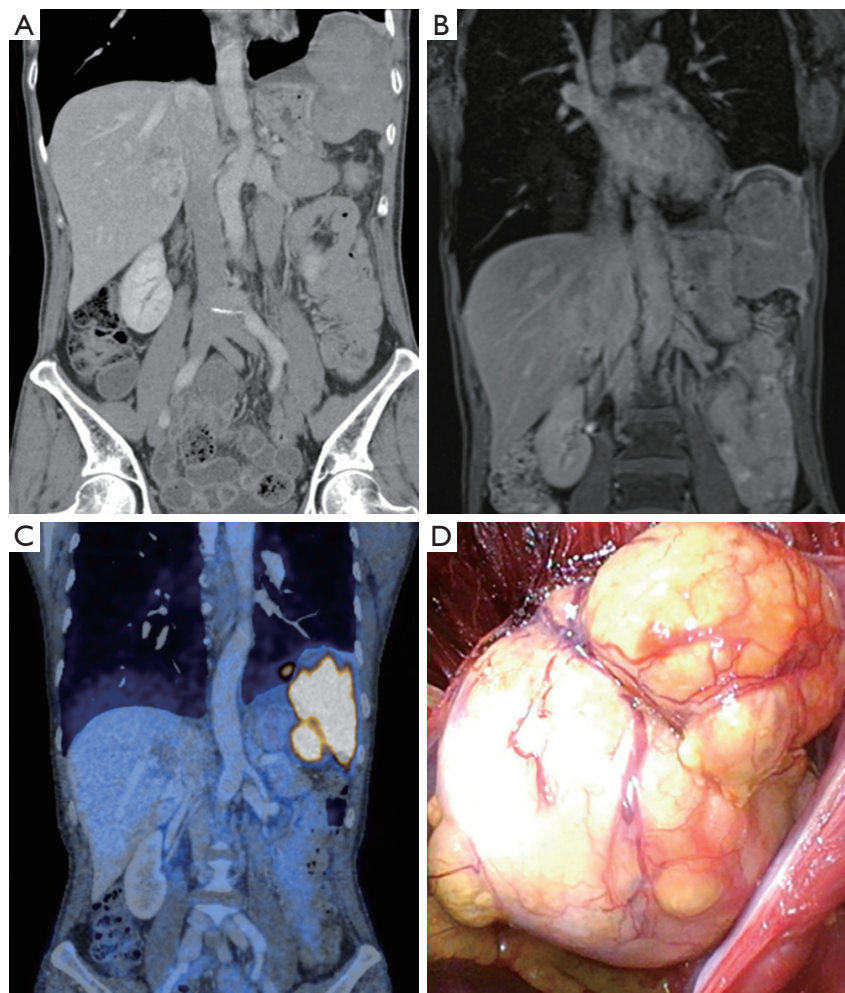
Pre-operative scans in coronal plane. (A) CT, (B) T1-weighted MRI and (C) ^{18}F -FDG-PET/CT demonstrating focus of left-sided MPM with transdiaphragmatic infiltration and slight displacement of the stomach, the spleen and the liver. (D) Intraoperative view of the resected bulky tumor (9.4 cm \times 5.8 cm).
